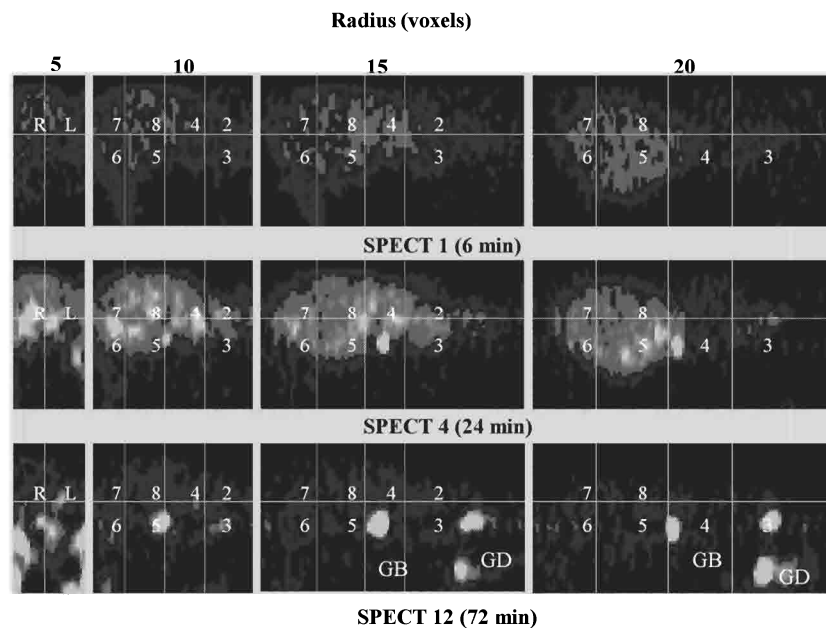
Activity/position graphs for sampling radii 5, 10, 15 and 20 of SPECT studies 1, 4 and 12. Segmental landmarks are drawn in and segments numbered. Note the presence of ductal peaks on SPECT 4 and gallbladder (GB) and gastro-duodenal (GD) activity on SPECT 12
